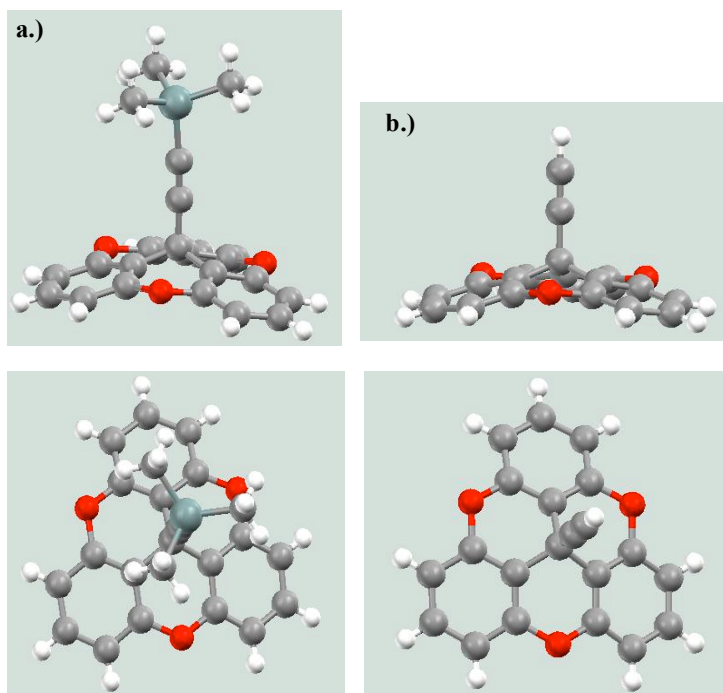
X-Ray structures of a.) TMS-alkyne derivative, triclinic P1(#2) R=0.069 b.) alkyne derivative, cubic Pa3(#205) R=0.062.
